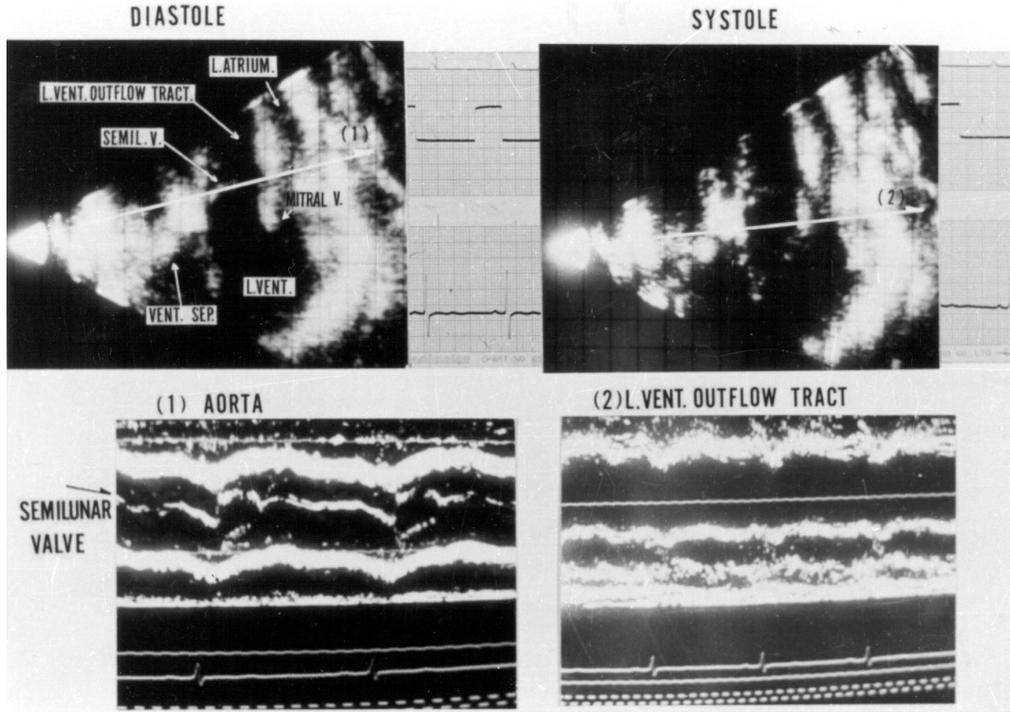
The M-mode and 2-dimensional echocardiograms obtained by the combination method. The target was the aortic valve and the LV outflow tract area. The aortic valve movement was caught for the first time by this method in 1965. White arrows on the tomograms show the ultrasonic beam direction for obtaining the M-mode image.
